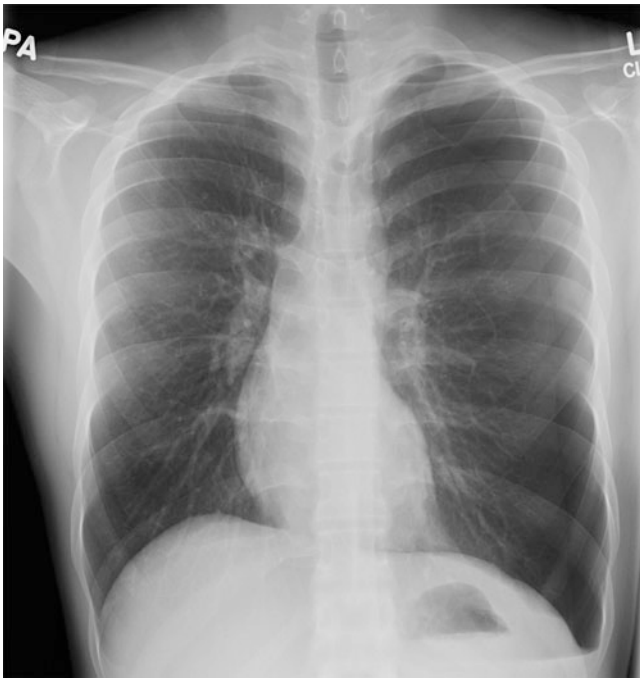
A PA chest radiograph demonstrating a moderate-sized left pneumothorax
